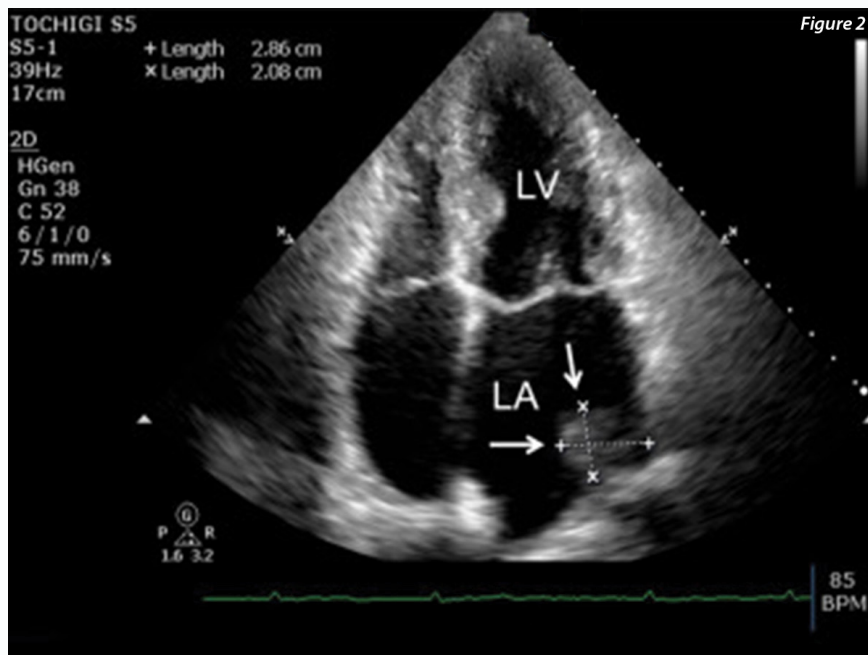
Echocardiogram showing hypoechoic mass in the left atrium.
